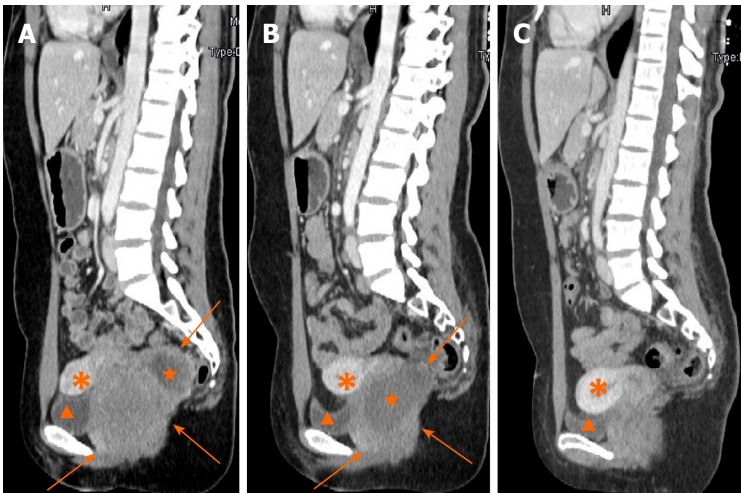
Contrast-enhanced computed tomography in sagittal section. A: A rectovaginal space mass of 8.0 cm in maximum diameter with non-enhancing liquefaction necrosis at the time of admission; B: The mass significantly shrunk to 6.4 cm in maximum diameter after 5 mo of imatinib treatment and non-enhanced liquefaction area enlarged clearly; C: No obvious sign of tumor recurrence in rectovaginal space 15 mo after tumor resection. Arrows: The mass; pentagrams: Liquefaction necrosis area; arrow heads: Bladder; asterisks: Uterus.
